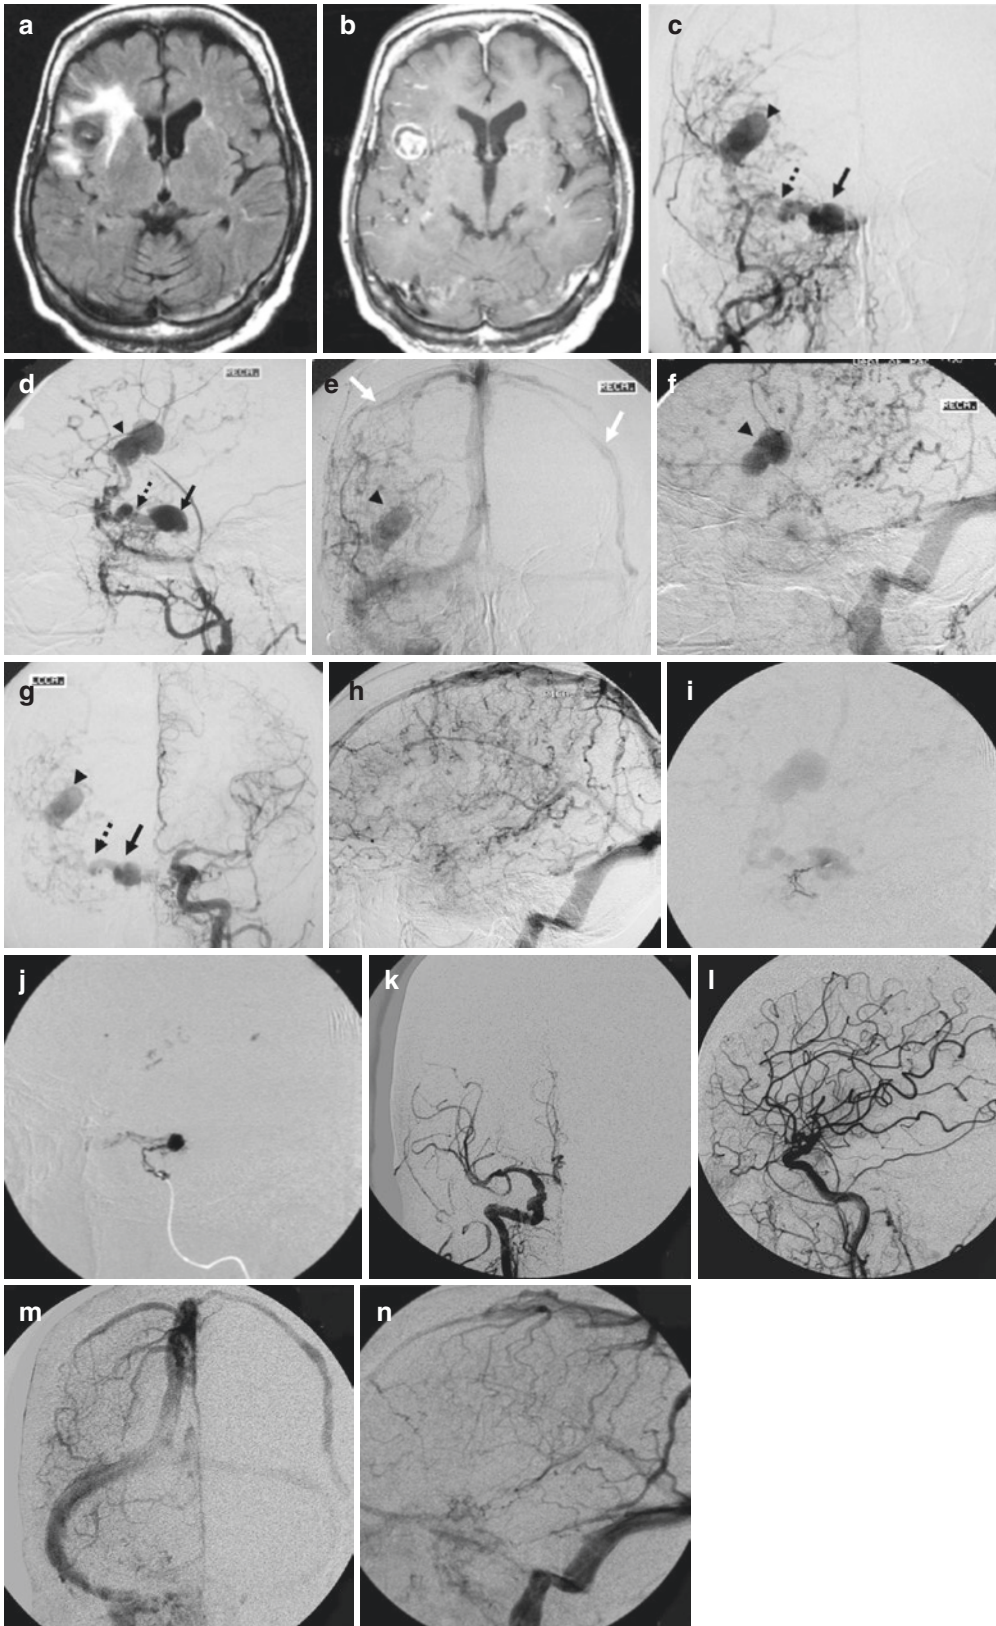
Transarterial glue embolization. (a, b) MRI of a 78-year-old female who presented with headache, diplopia, and right lateral rectus palsy showing a partial thrombosed aneurysmal mass with perifocal edema at the right frontal operculum. (c, d) Right ECA angiogram revealing right dCCF (arrow) with SMCV (dashed arrow) drainage only, causing significant cortical reflux with dilated venous pouch (arrowhead). Note no visualization of the SOV or IPS. (e, f) Same injection as in (c, d) showing stagnation of venous pouch (arrowhead) with retrograde cortical reflux draining into the superior sagittal sinus and epidural veins (white
